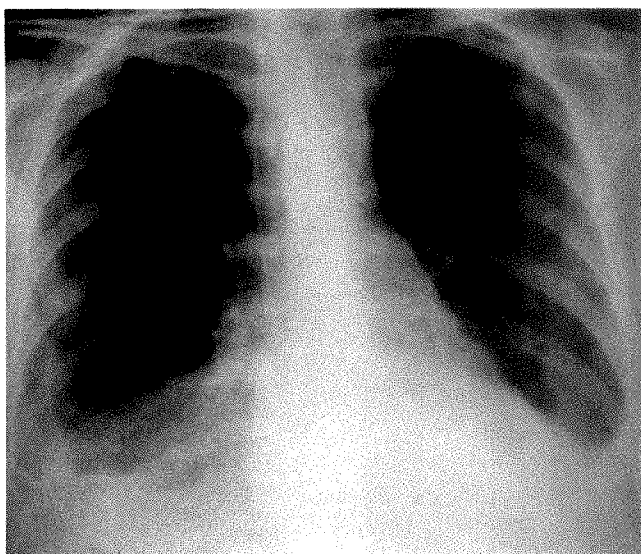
42-year-old woman with metastatic renal cell carcinoma. Radiograph obtained 5 days after treatment was started shows moderate bilateral pleural effusions. Interstitial pulmonary edema developed subsequently.
